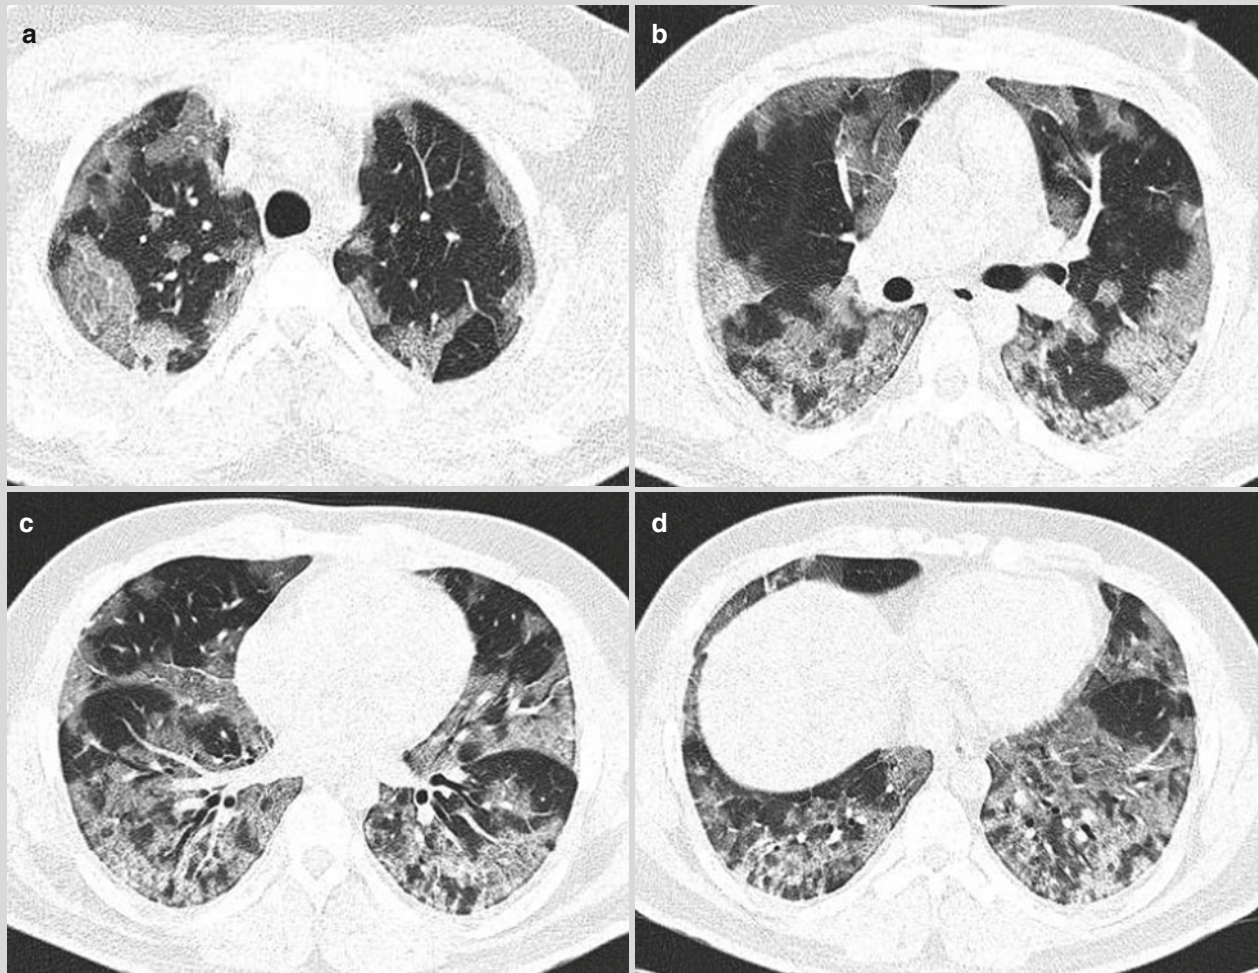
CT scan showed sporadic flakes of high density opacity and ground glass opacity that were predominantly in bilateral lower lungs lobes as well as consolidation of partial lung tissues with gas containing bronchi (a–d)
